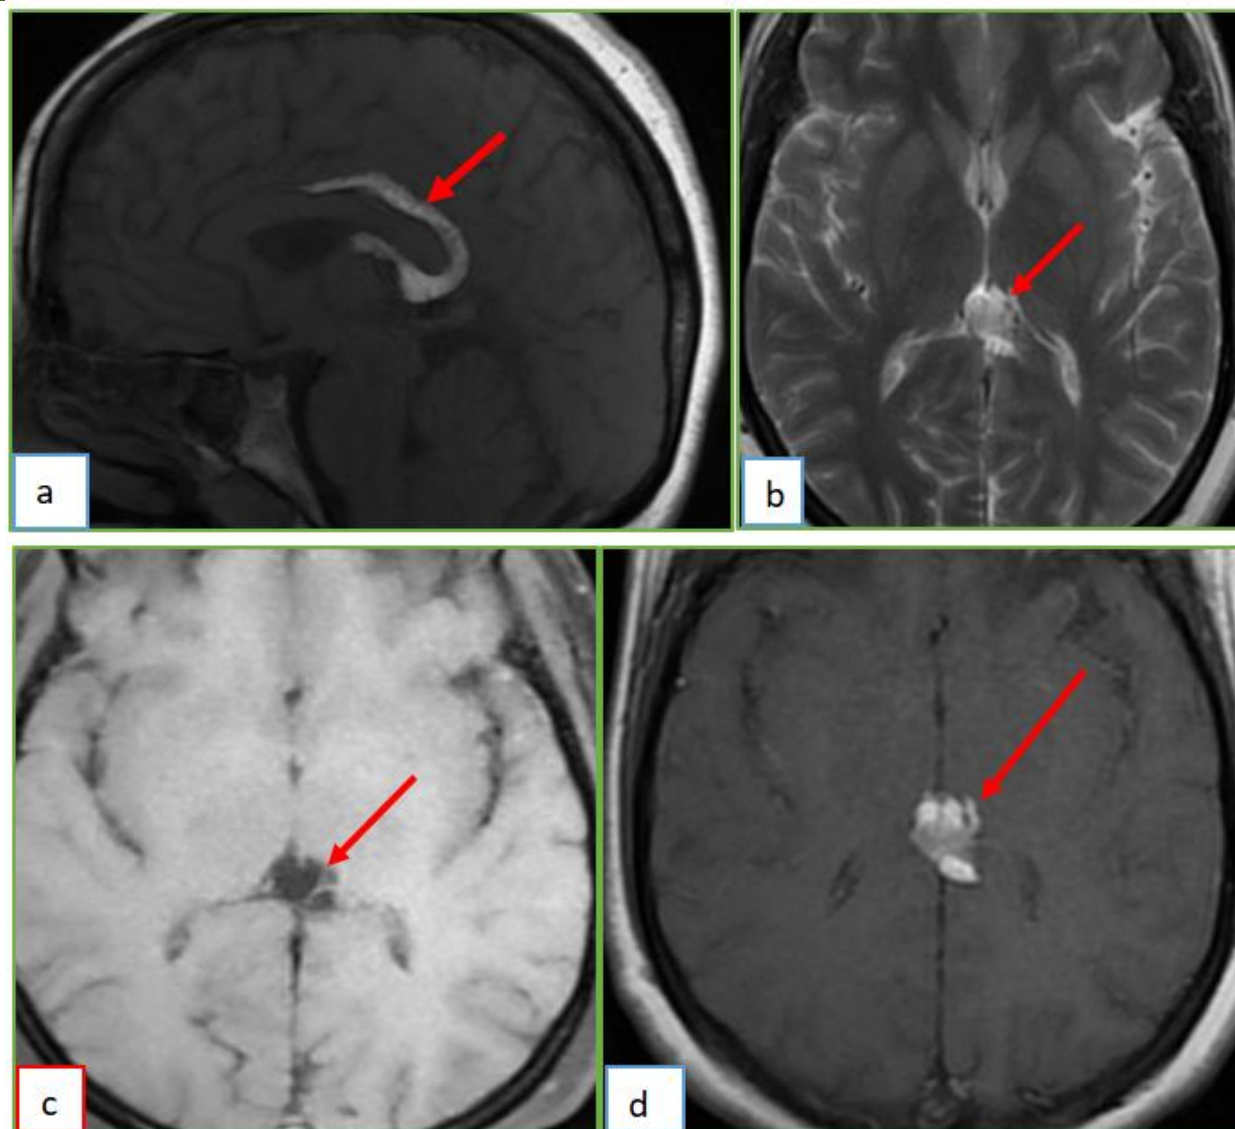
Brain MRI with sagittal T1FSE(a) axial T2(b) etT1(d)FSE and axial T1FatSat: demonstrate a curvilinear pericallosal lipoma (red arrows), appear in T1 and T2 hyper signal, with a drop in signal on T1 Fat Saturation sequence
